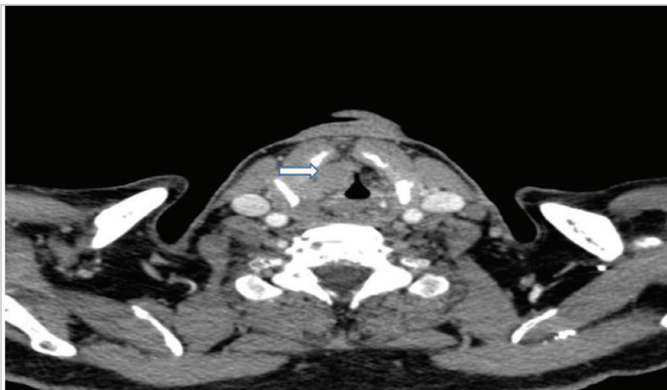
Computed tomography of the neck with contrast in the preoperative period (axial image). The mass is indicated by a white arrow
